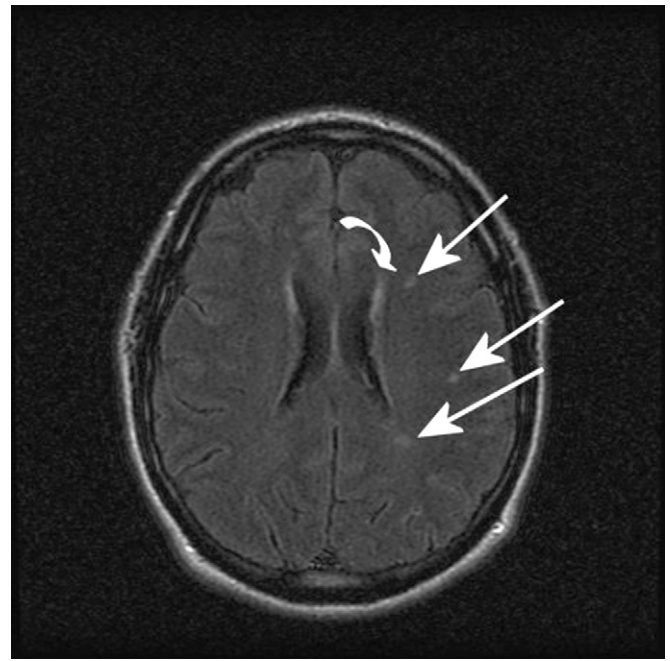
FLAIR MRI image demonstrating punctate areas of hyperintensity within the brain (straight arrows). Lesions are located predominately along gray-white matter junctions of the inferior-lateral left frontal lobe. A similar lesion is noted in the periventricular white matter along the left atrium of the ventricle (curved arrow). Lesions do not enhance (images not shown) and are most consistent with gliotic foci secondary to microvascular ischemic changes.
